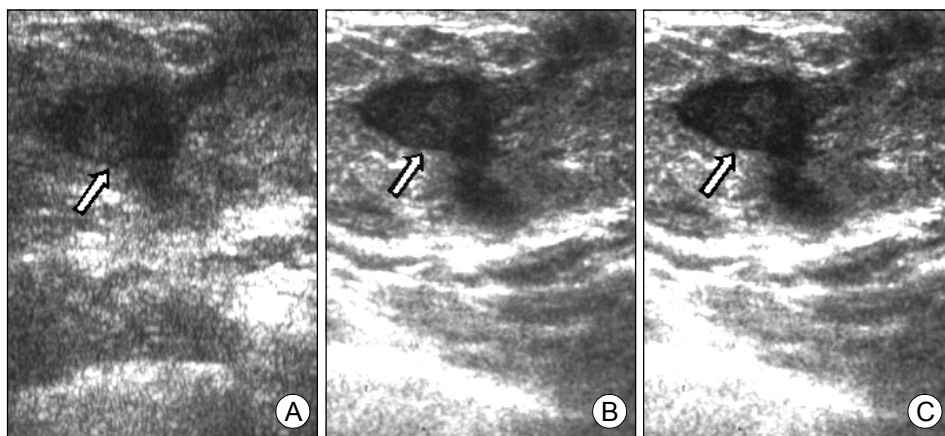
28-year-old female with breast abscess. Ultrasonograms show an ill-defined oval shaped hypoechoic nodule (arrows) in subareolar area. Survey (B) and target (C) modes of RTCI are superior to CI (A) in terms of clarity of the margin and internal echoes of nodule.
